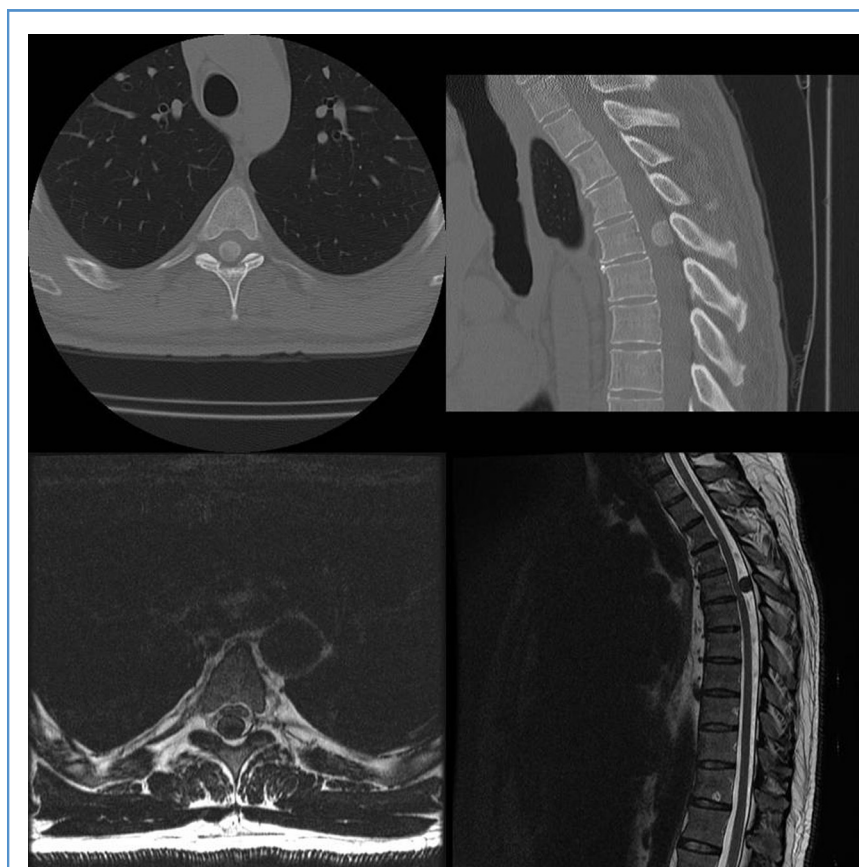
Axial (left) and sagittal (right) computed tomography (upper) and magnetic resonance imaging (lower) scans of a 44-year-old man presenting with slowly progressive myelopathy secondary to a homogeneously calcified meningioma.
